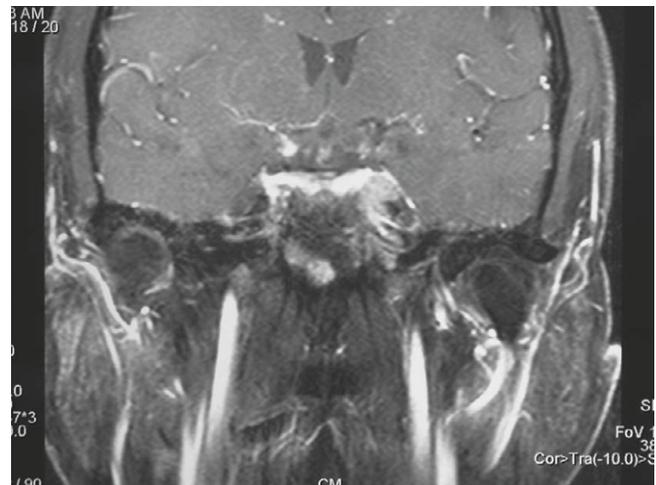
Coronal view of T1-weighted magnetic resonance imaging with gadolinium enhancement, which was performed 3 months after the initial imaging, shows a tumor in the left cavernous sinus.
